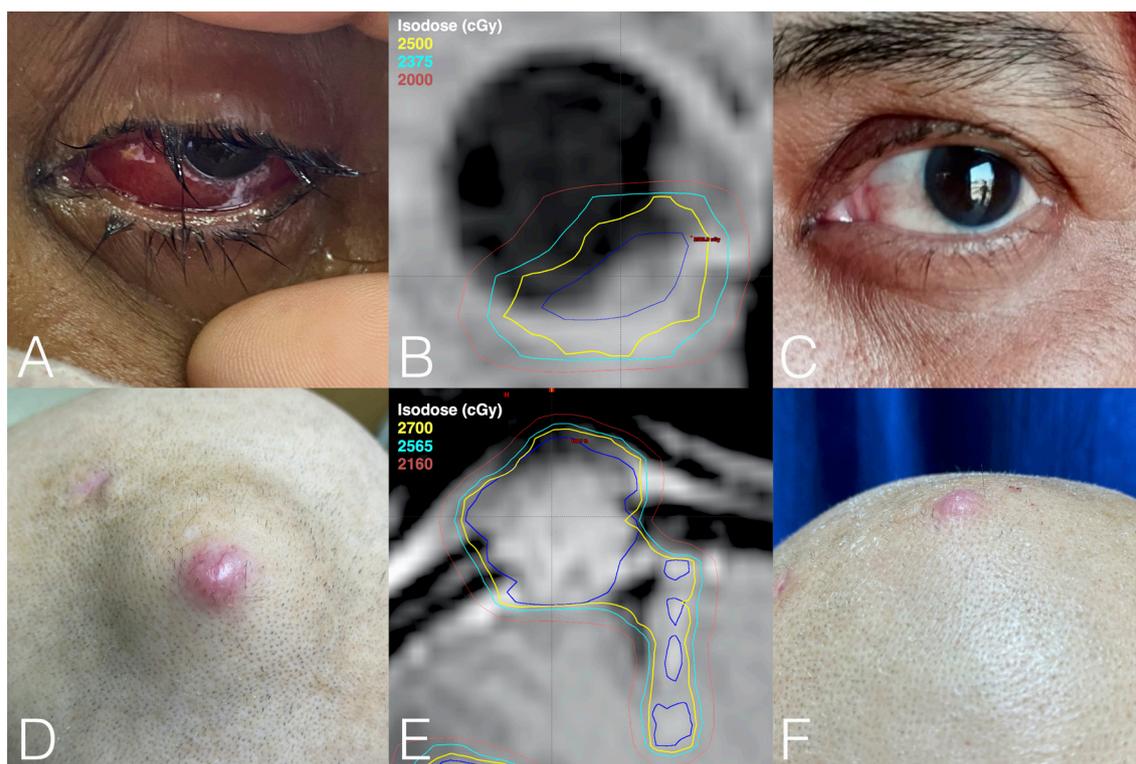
Patient and fractionated stereotactic radiotherapy (FSRT) planning images. (A–C) Pretreatment patient image, FSRT plan superimposed on sagittal MP-RAGE (Magnetization Prepared - RApid Gradient Echo) MRI sequence and Post-treatment (1 month) patient image, respectively. (D–F) Pretreatment patient image, FSRT plan superimposed on sagittal MP-RAGE MRI sequence and Post-treatment (2 weeks) patient image, respectively. In images (B) and (D): gross tumour volume—blue contour; isodoses corresponding to 100%, 95%–80% of prescribed dose—yellow, cyan and pink, respectively.
